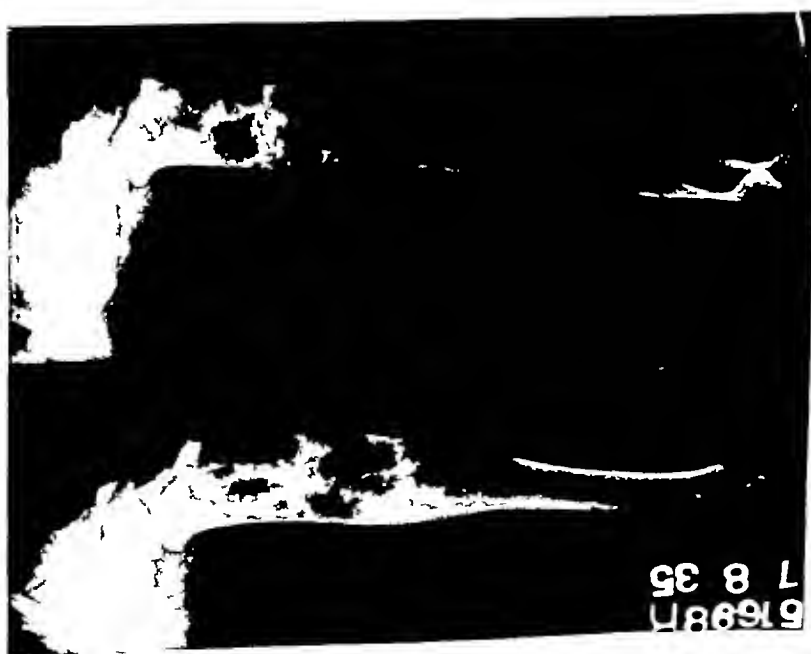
Roentgenogram taken on July 8 1935 shows the fracture healed in good position There is a beginning recalcification of the cysts
